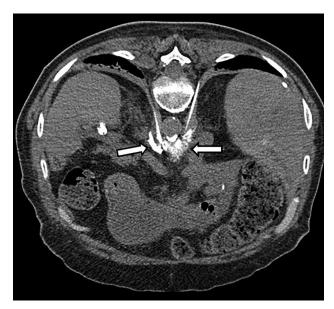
Single axial intraprocedural CT image demonstrates diffusion of contrast material around the celiac plexus just before ethanol injection (arrows).
